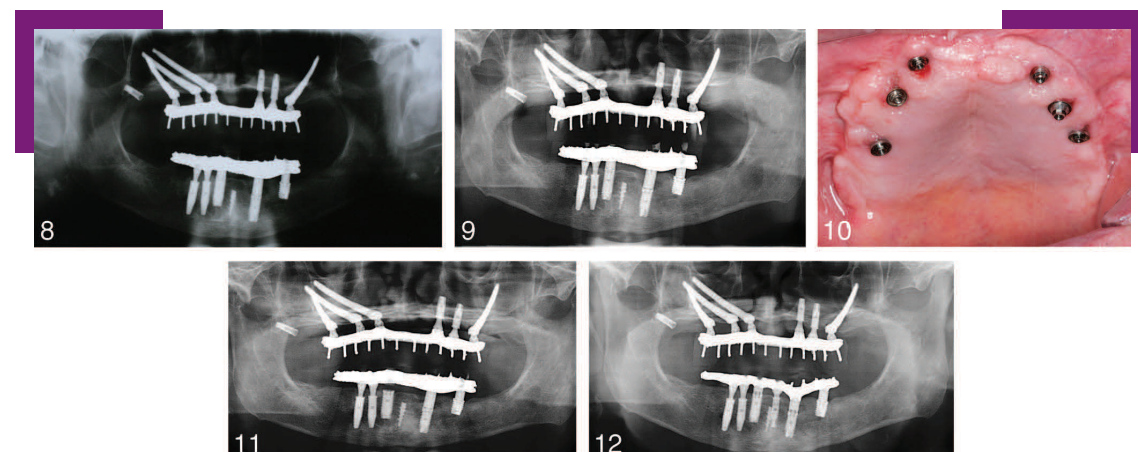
Radiographical follow-up at 9 months postsurgery. Figure 9. Radiographical follow-up at 17 months postsurgery. Figure 10. Clinical follow-up at 28 months postsurgery. Figure 11. Radiographical follow-up at 36 months postsurgery. Figure 12. Radiographical follow-up at 55 months postsurgery.
